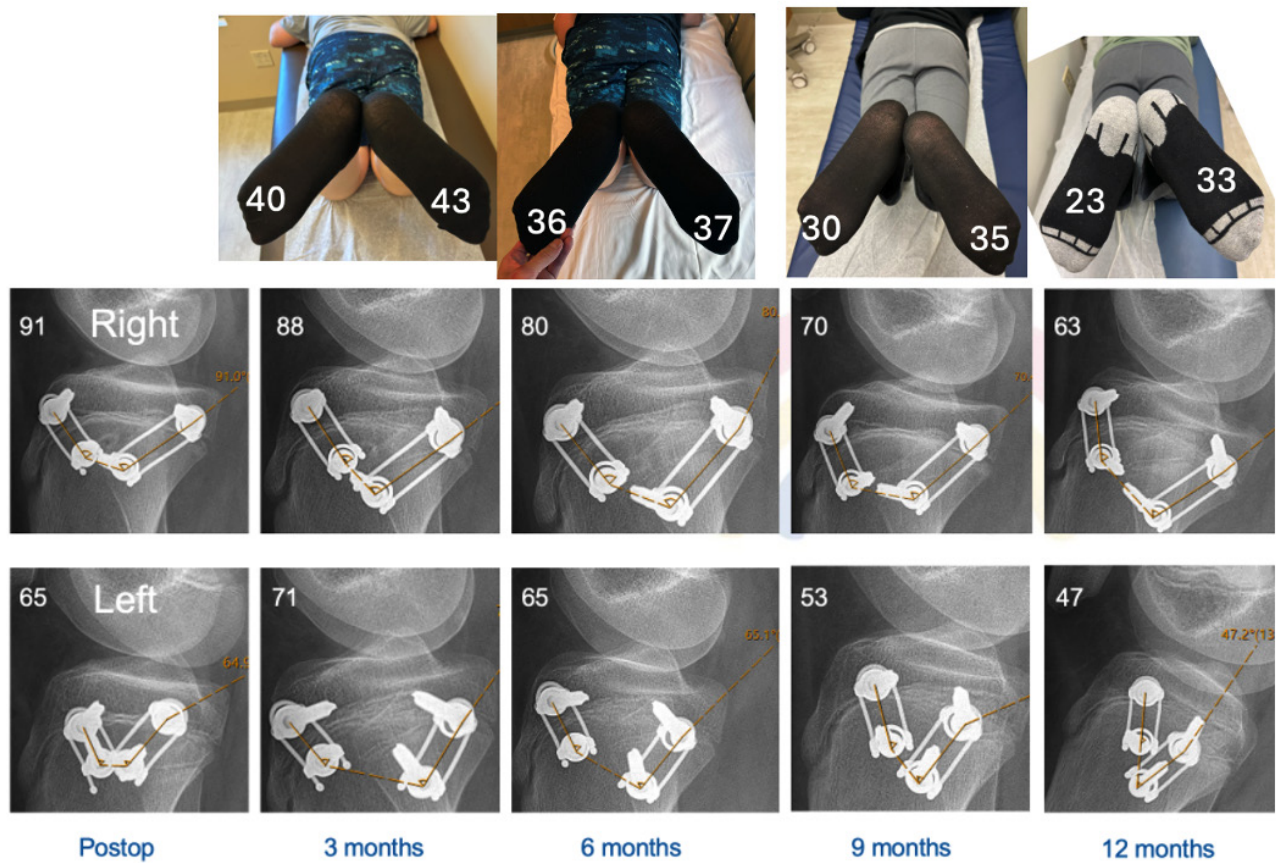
Photographs and radiographs of a 12-year-old male with bilateral external tibial torsion demonstrates progressive decrease in construct angle and decrease in thigh foot angle at each visit. Degrees of measurement are labeled on each image.
